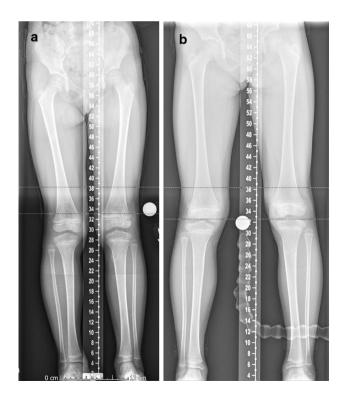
Long-leg radiographs taken a 12 and b 24 months post-operatively, confirming equal leg lengths without angular deformity or physeal growth arrest
